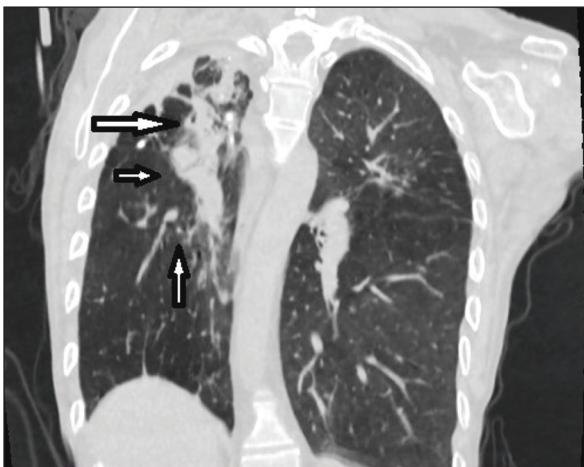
CT of the chest Homogeneous opacification in the right upper lobe from probably pleural encapsulation, gross fibro indurative changes hyloapically with intrafocal mesthymic small calcifications on the right, at that level with elevation of the hilus. Trachea and mediastinum drawn to the right, as well as the cardiac silhouette
